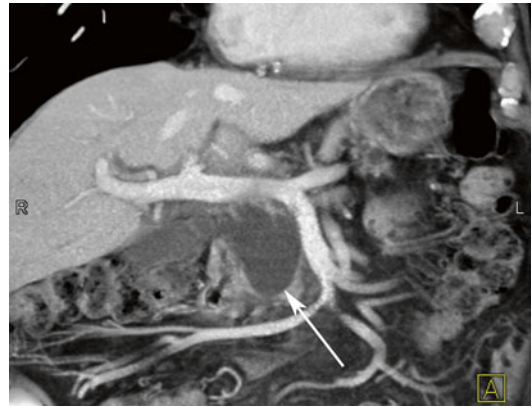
Coronal volume-rendered contrast-enhanced CT demonstrates a large cystic lesion (*arrow*) in the pancreatic head which was shown to communicate with the main pancreatic duct (not shown), compatible with a side-branch IPMN
